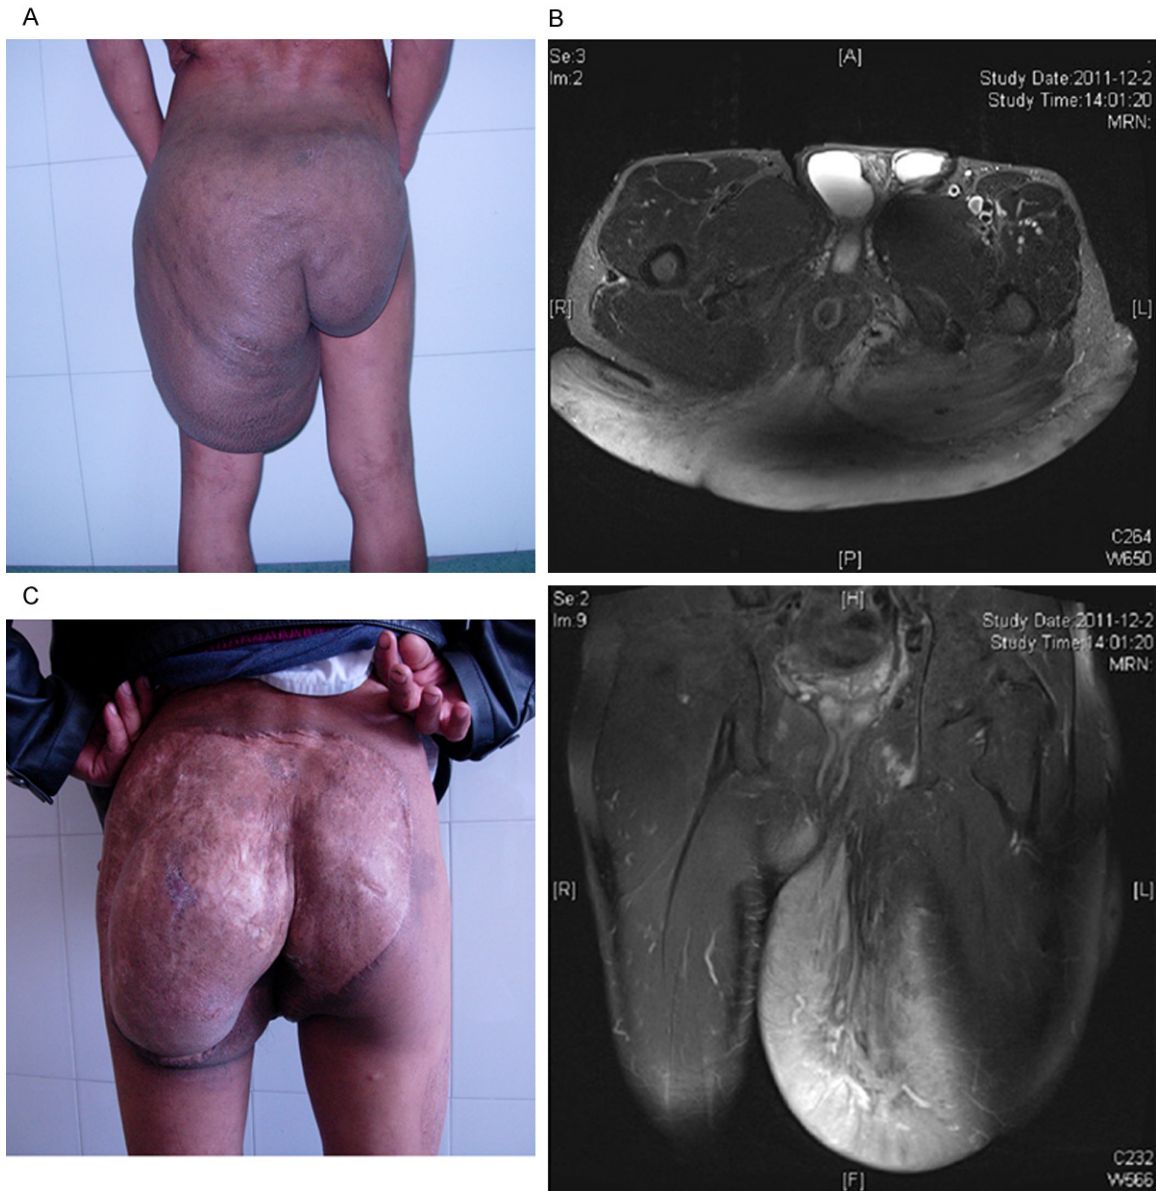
Case 4. A 55-year-old man had a giant neurofibroma in the hips (A). MRI showed that the tumor was located on the gluteus maximus muscle (B). The tumor was almost completely resected and the wound was repaired by skin graft (C).
